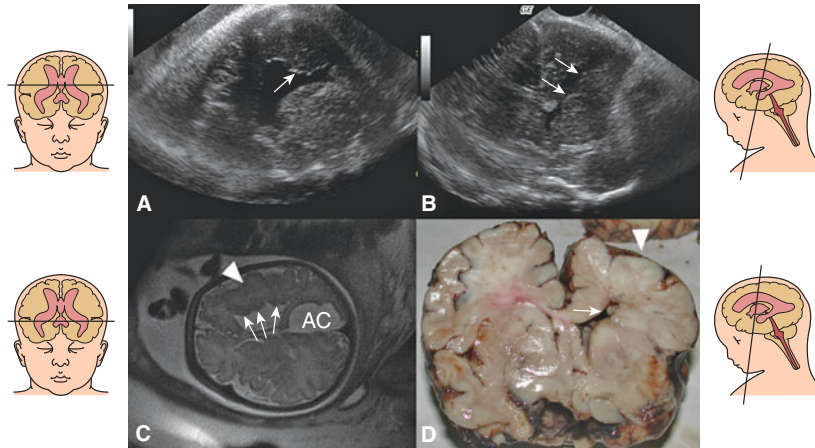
Focal unilateral parietal agyria with periventricular heterotopia in a fetus at 40 postmenstrual weeks referred for evaluation of a large interhemispheric arachnoid cyst. (A) Nonorthogonal view of the affected side shows irregular ventricular wall with abnormal brain tissue bulging into the ventricle (arrow). (B) Coronal view at the level of the third ventricle shows the irregular ventricular wall (arrows); note the lack of normal sulci on the affected side. (C) Axial MRI demonstrates the periventricular heterotopia (arrow), with the pachygyric overlying cortex (arrowhead) and the posterior interhemispheric arachnoid cyst (AC). (D) Macroscopic pathology confirms the presence of heterotopia (arrow) and pachygyria (arrowhead).
